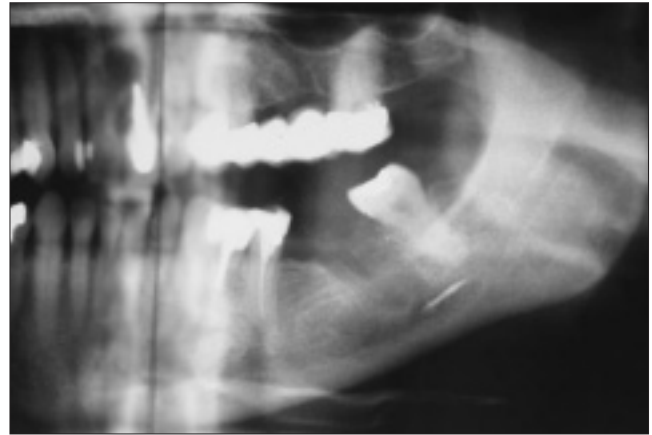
Panoramic radiograph showing radiopaque material in the inferior alveolar canal region.
